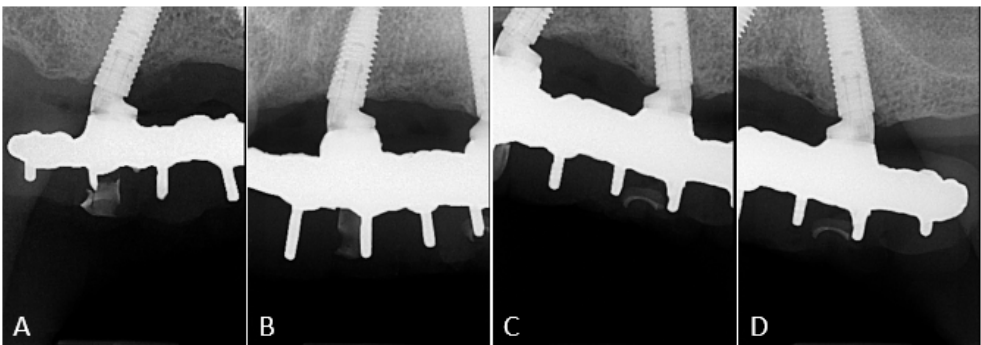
Periapical x-rays of maxillary implants at 16-month follow-up.
